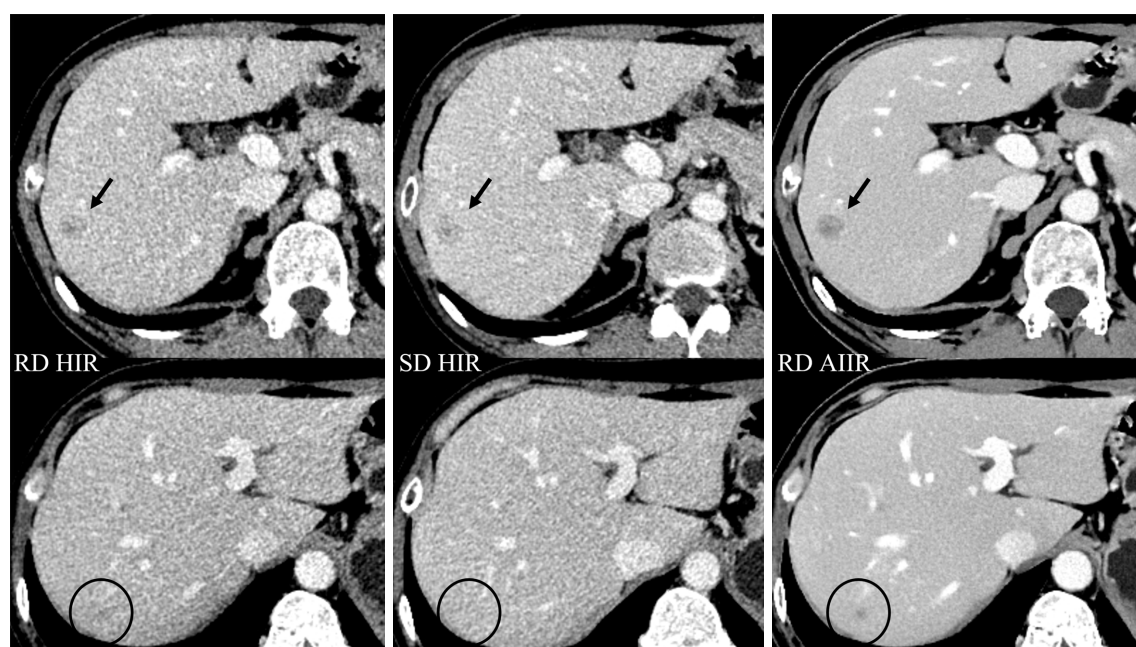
Axial contrast-enhanced CT images of the abdomen in a 49-year-old woman with two liver metastases in hepatic segment 6. A 14-mm low-contrast lesion (black arrows) was detected by both readers, and the CNRs for RD HIR, SD HIR, and RD AIIR were 1.5, 2.2, and 3.4, respectively. A 4-mm lesion (circles) was missed with RD HIR and SD HIR by both readers but was detected with RD AIIR; the scores from reader 1 and reader 2 were 3 and 4, respectively. RD, reduced dose; SD, standard dose; HIR, hybrid iterative reconstruction; AIIR, artificial intelligence model-based iterative reconstruction; CNR, contrast-to-noise ratio; CT, computed tomography.
